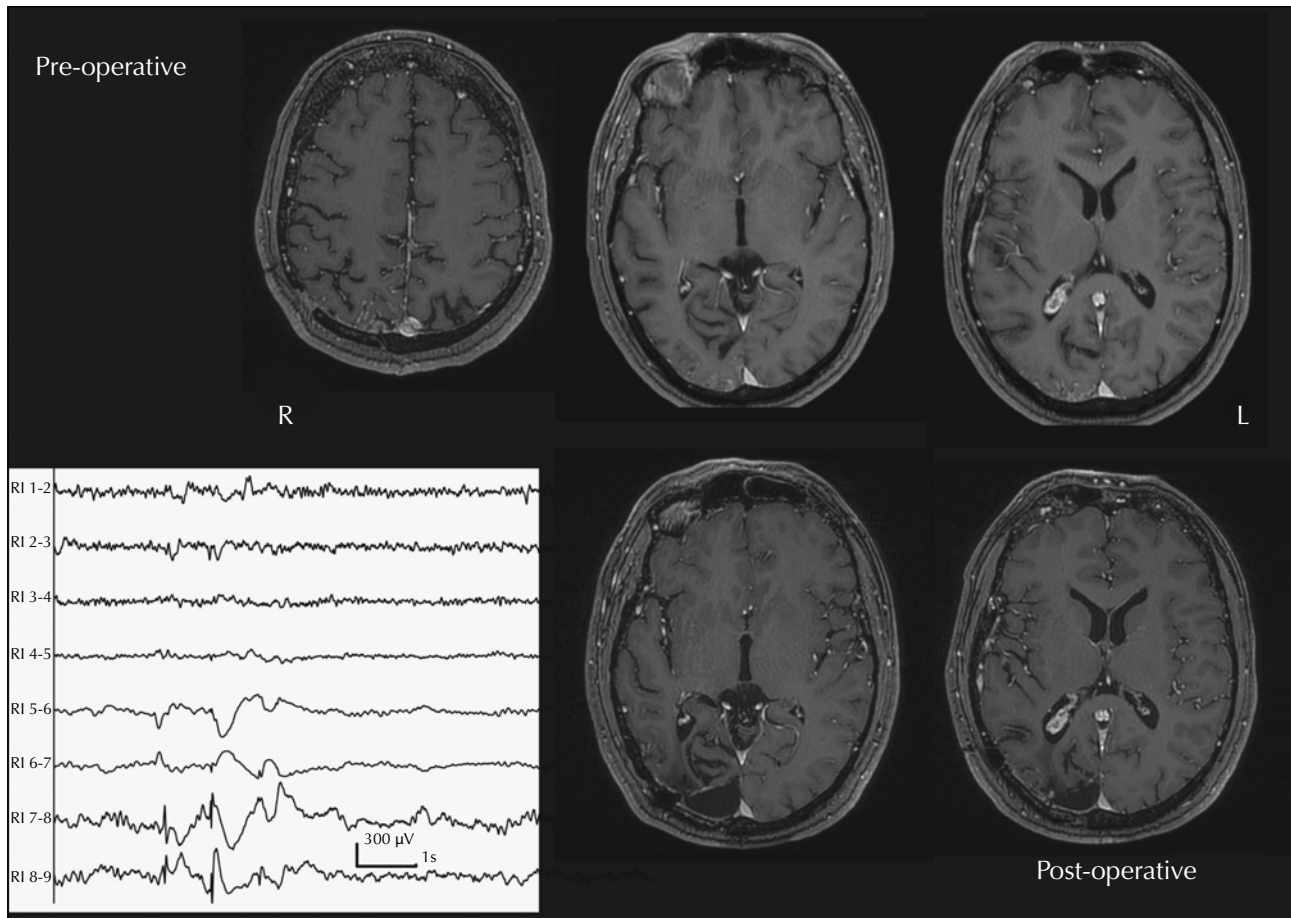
The preoperative MRIs in the upper row show clear signs of SWS: enhancement of the pial structures, gliotic changes in the underlying cortex and an enlarged choroid plexus. In the lower row, in the post-operative MRI after the first surgery, the surgical cavity as well as the remaining lesion are clearly visible. The intracranial EEG shows interictal spike-slow-waves over the most external contacts of RI, which is the infralcalcarine electrode.
